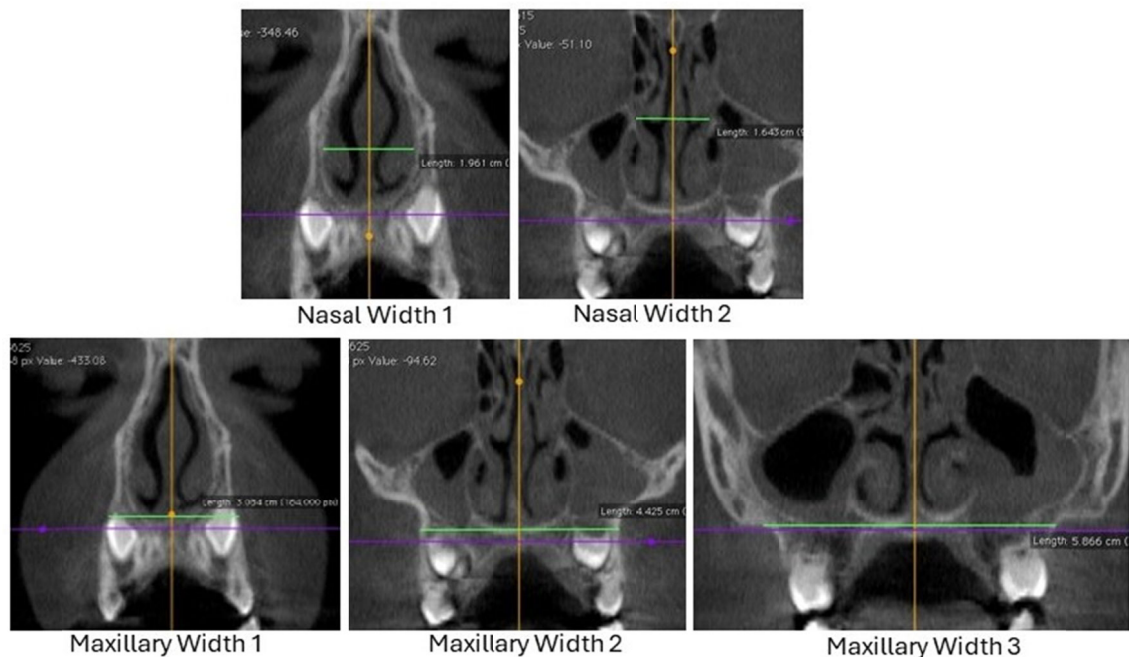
Nasal and maxillary widths measured in coronal sections of CT scans: nasal width 1 (N1), nasal width 2 (N2), maxillary width 1 (M1), maxillary width 2 (M2) and maxillary width 3 (M3).
